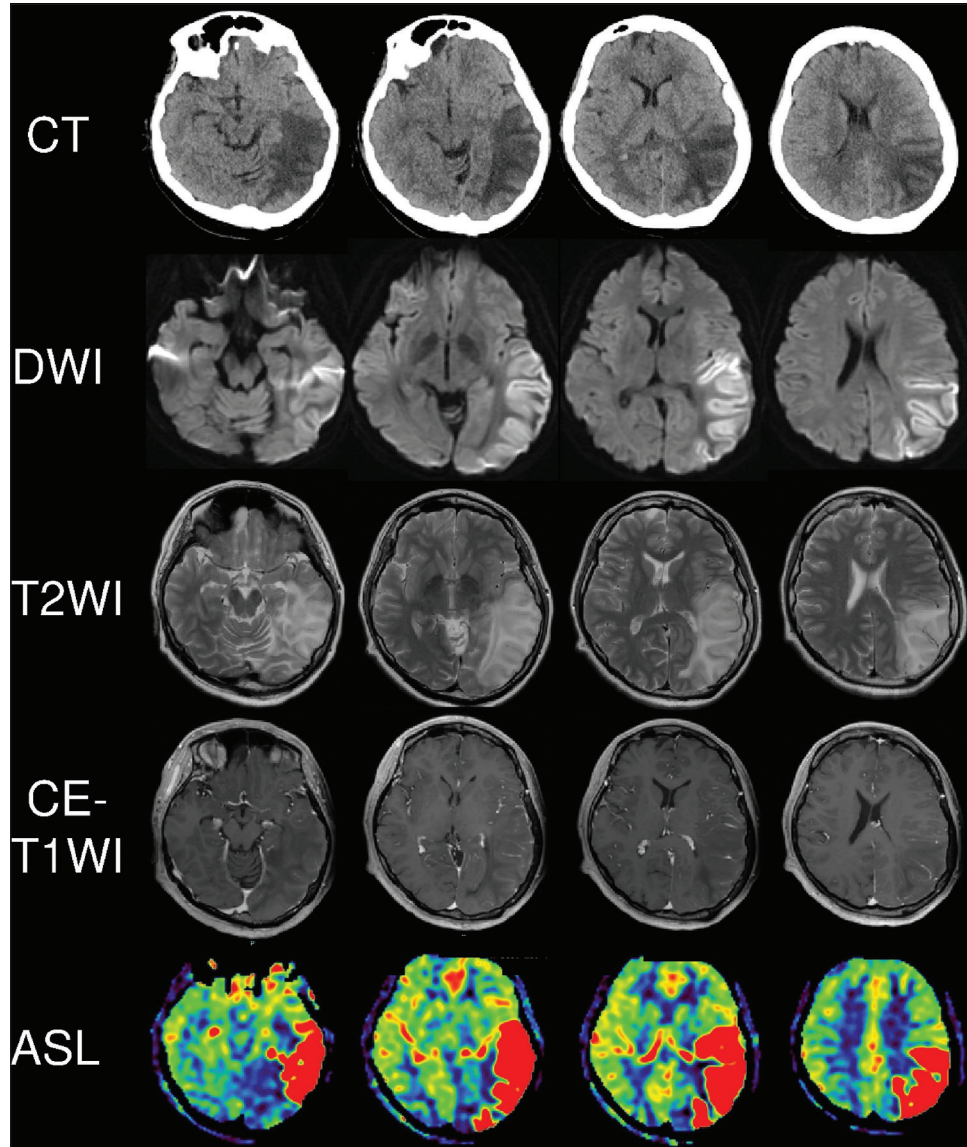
Neuroimaging on day 29. Head computed tomography revealed a further enlarged low-density area from the left parieto-occipital lobe to the temporal lobe. The diffusion-weighted image and T2-weighted image also showed the enlarged high-intensity area. Gadolinium-enhanced T1-weighted image reveal that the lesion was not enhanced and arterial spin labeling image described strong cerebral blood flow increase in the same region.
